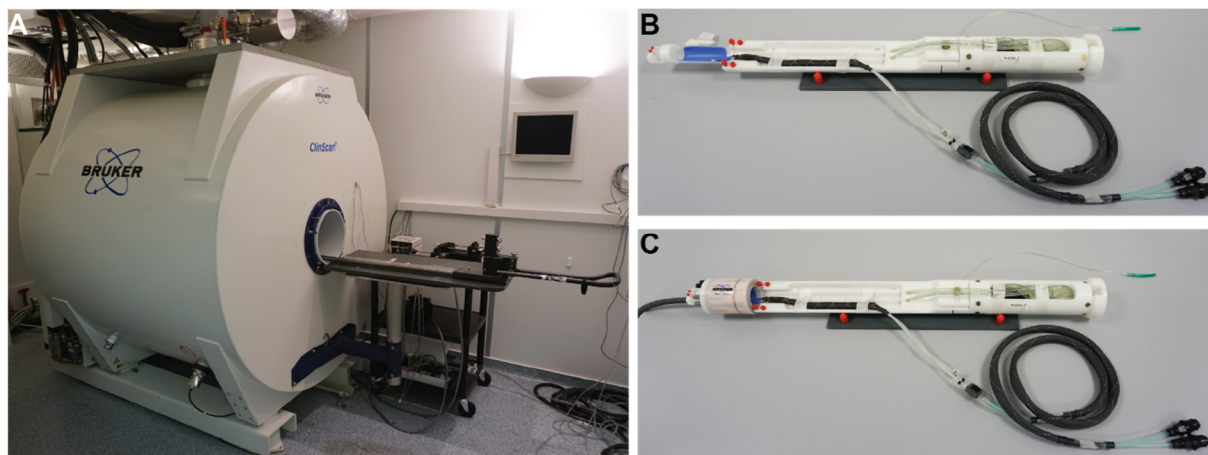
Experimental setup for simultaneous PET/MRI acquisitions.
